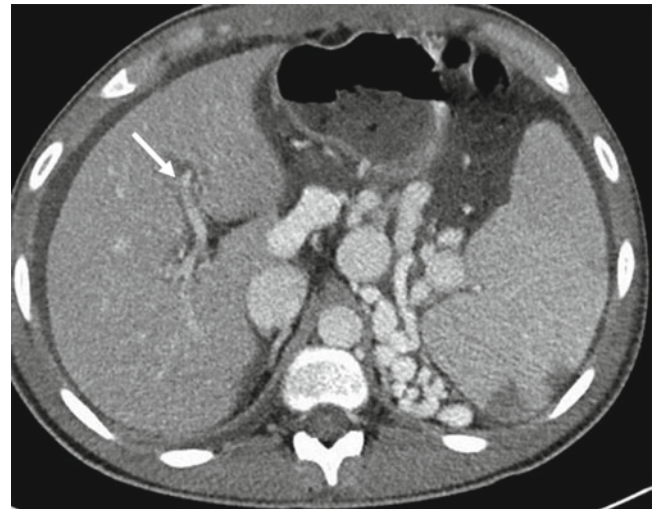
Postoperative abdominal CT showing increase in size of the intrahepatic portal vein following MRB (white arrow)
